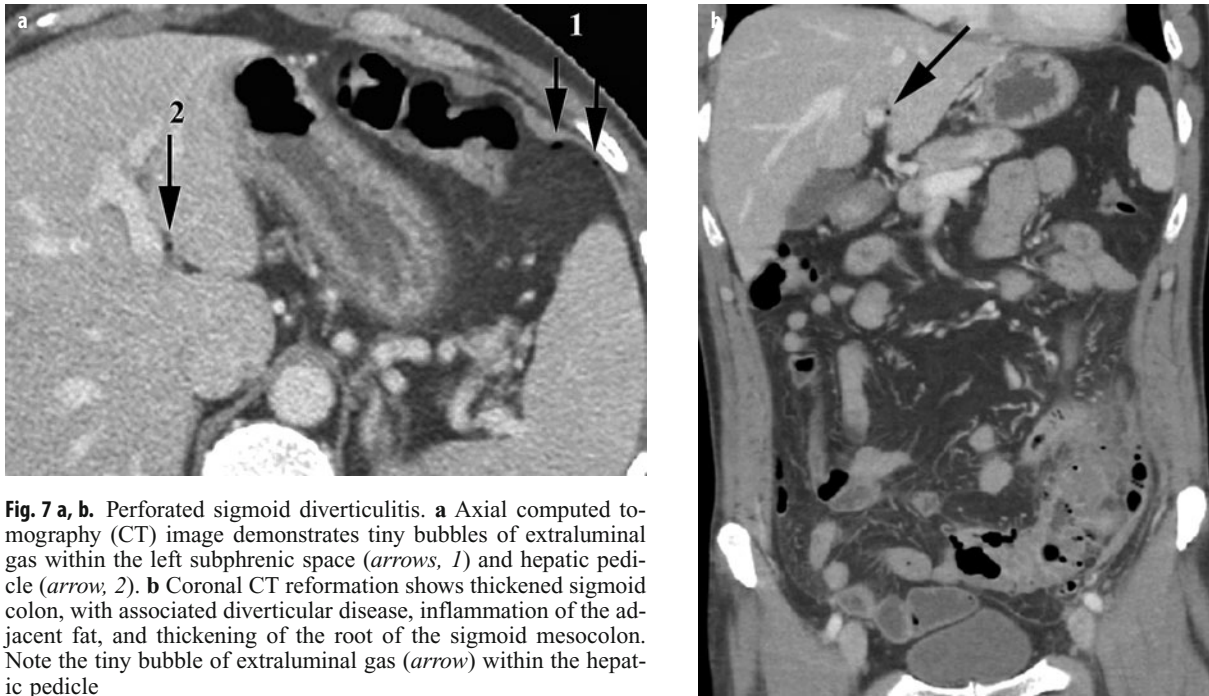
a, b. Perforated sigmoid diverticulitis. a Axial computed tomography (CT) image demonstrates tiny bubbles of extraluminal gas within the left subphrenic space (arrows, 1) and hepatic pedicle (arrow, 2). b Coronal CT reformation shows thickened sigmoid colon, with associated diverticular disease, inflammation of the adjacent fat, and thickening of the root of the sigmoid mesocolon. Note the tiny bubble of extraluminal gas (arrow) within the hepatic pedicle
